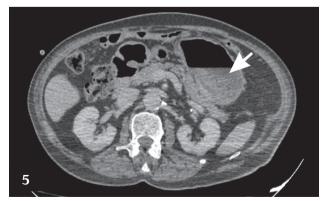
CTA: Axial image in the portal venous phase. In the lower part of the gastric body, sedimentation of hyperattenuating material (arrow) due to blood products is shown.
